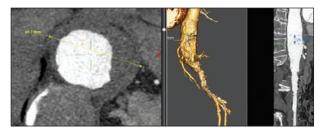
Preoperative CT scan showing a TAAA with a maximum extent of 70 mm.
